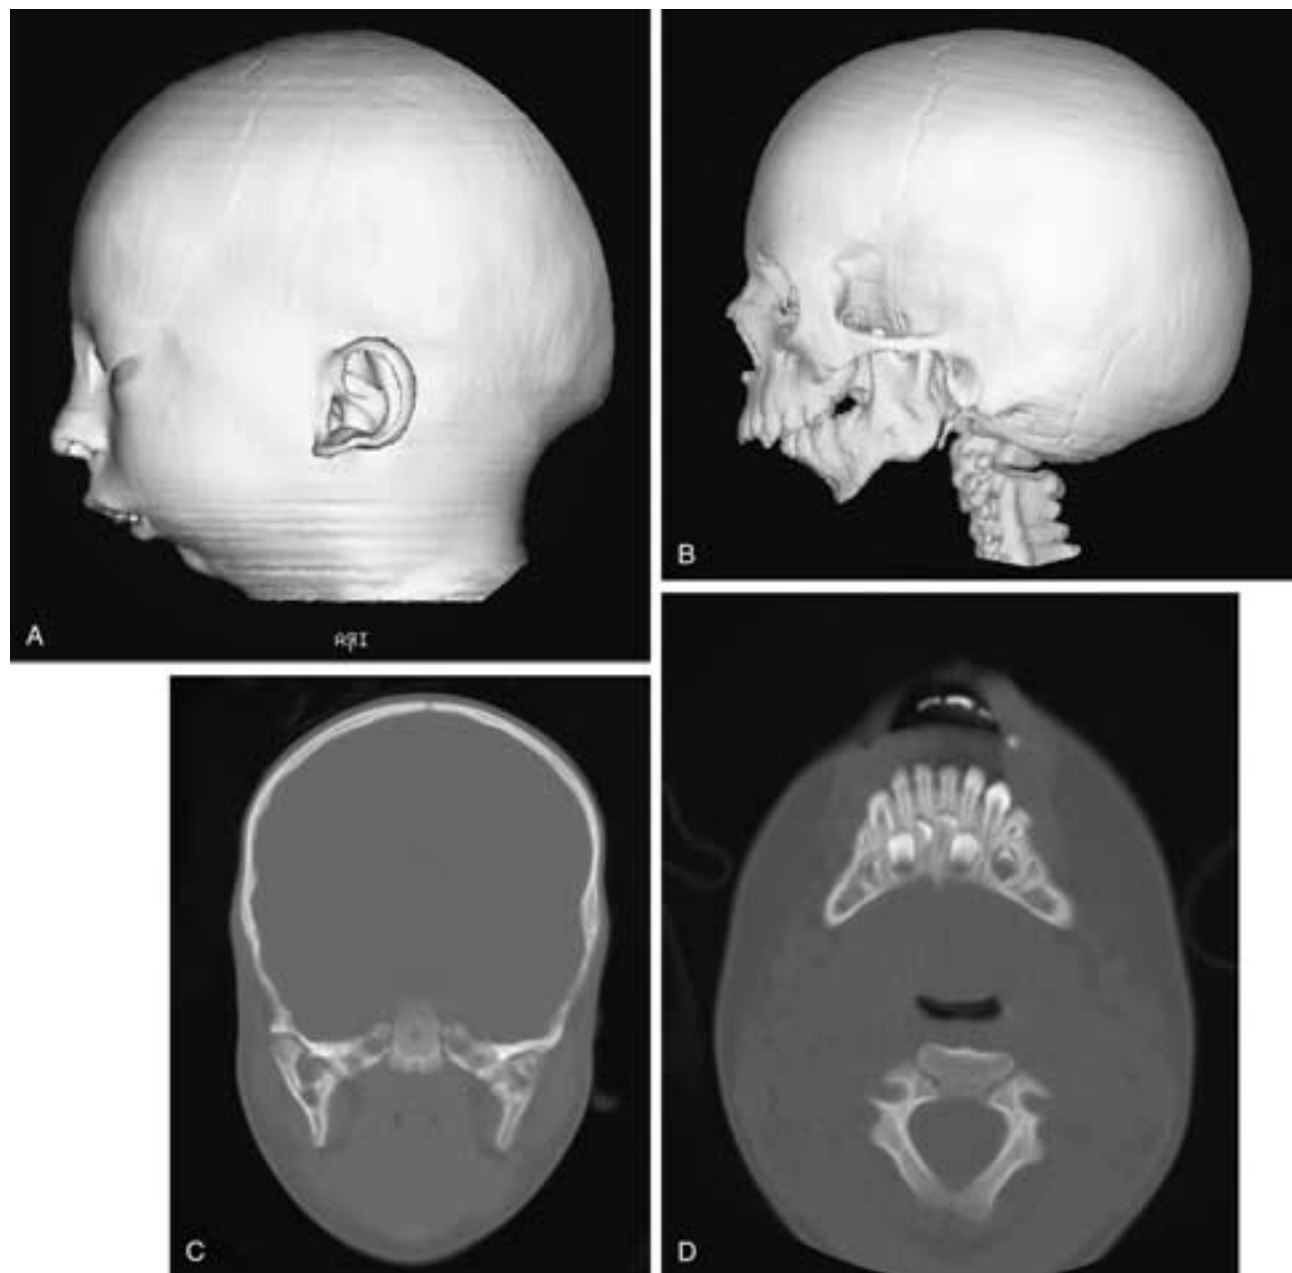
Pierre Robin sequence in a 2½-year-old boy with no catch-up growth of the mandible. A and B, Lateral 3D CT of the skin surface (A) and facial skeleton (B) show severe retrognathia and micrognathia. C, Coronal bone CT shows marked butressing of the mandibular condyle. D, Axial CT section shows a vertical orientation of the maxillary incisors but a horizontal course of the mandibular dentition.
